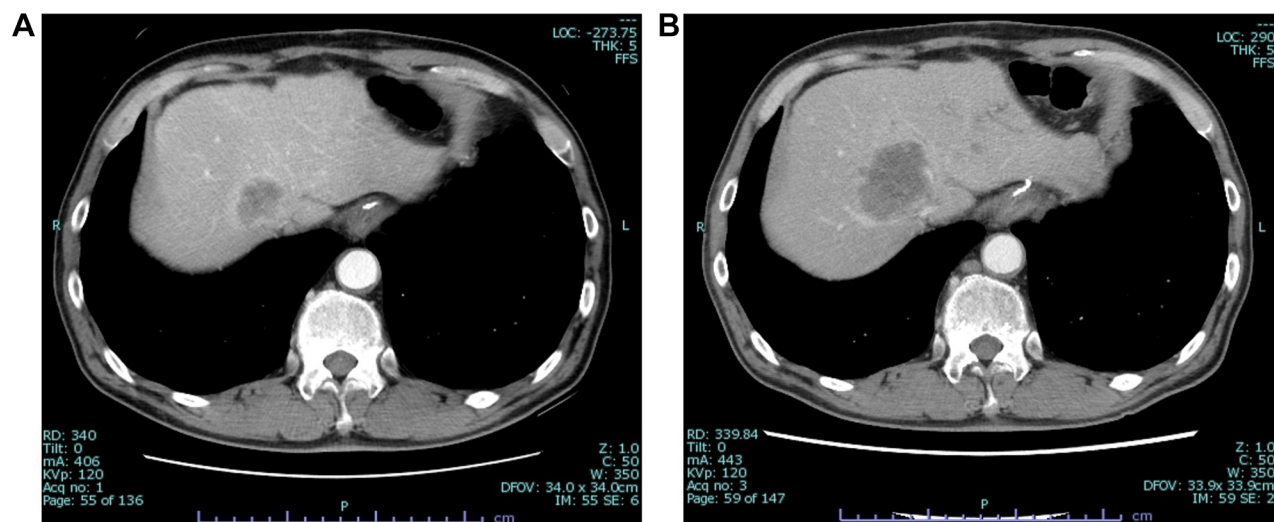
Representative computed tomography (CT) images in a patient with high tumor growth rate. A) CT image before starting second-line chemotherapy. B) CT image after several courses of second-line chemotherapy.
